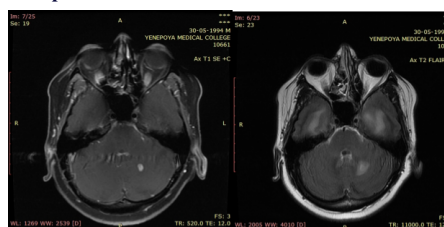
This was a case of TB meningitis showing a enhancing nodular lesion in the left cerebellar hemisphere on post contrast axial T1 fat sat images whereas the leptomeningeal enhancement in the basal cistern as seen on axial post contrast T2 FLAIR.
